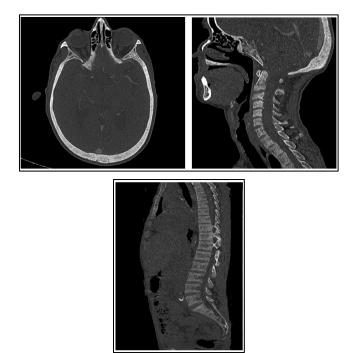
CT scan of the brain and the entire spine in bone window showing osteocondensation of the plateaus of the vertebral bodies of the entire spine, giving a "rugby shirt spine" appearance, with multiple microlytic lesions of the skull bones, giving a salt-and-pepper appearance related to renal osteodystrophy.
